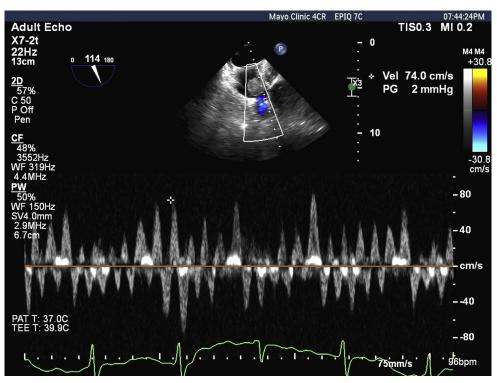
Pulsed-wave Doppler signal recorded from the ostium of the LAA demonstrated normal LAA emptying velocity (74 cm/sec).
